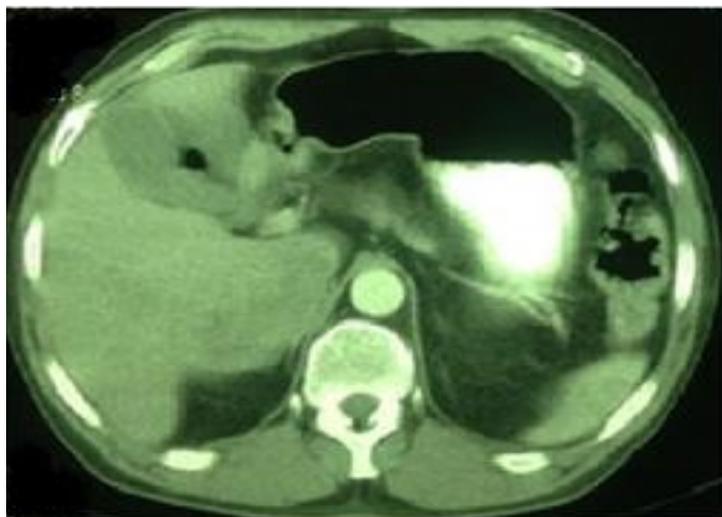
In this view of abdominal contrast CT scan, the multiple lesions in liver decreased in size significantly (after Imatinib)
